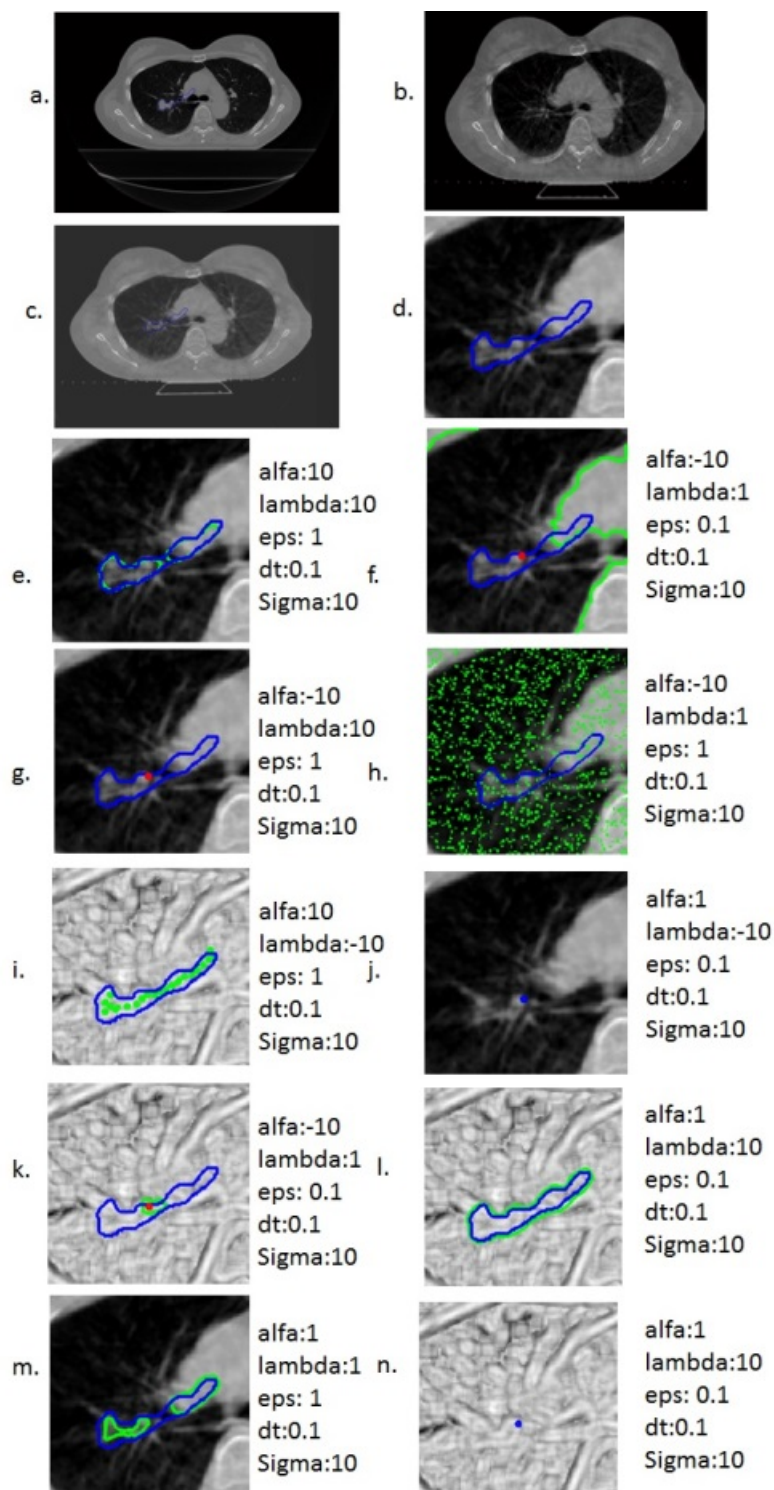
Performance of different combinations with different parameters for lung CBCT image tumour segmentation, Patient 2-Slice 42: a. planning-CT, b. CBCT #1, c. cropped part of of part c with clinical GTV, d. Li model on CBCT using GTV as its initial contour, e. Chan-Vese model on CBCT using centre of GTV as its initial contour, f. Li model on CBCT using centre of GTV as its initial contour, g. Chan-Vese model on texture image using GTV as its initial contour, h. Li model on PCA image using GTV as its initial contour, i. Chan-Vese model on vector-valued texture image using centre of GTV as its initial contour, j. Li model on PCA image using centre of GTV as its initial contour, k. Chan-Vese model on PCA image using GTV as its initial contour, l. Chan-Vese on CBCT using GTV as its initial contour and m. Chan-Vese model on PCA image using centre of GTV as its initial contour.
